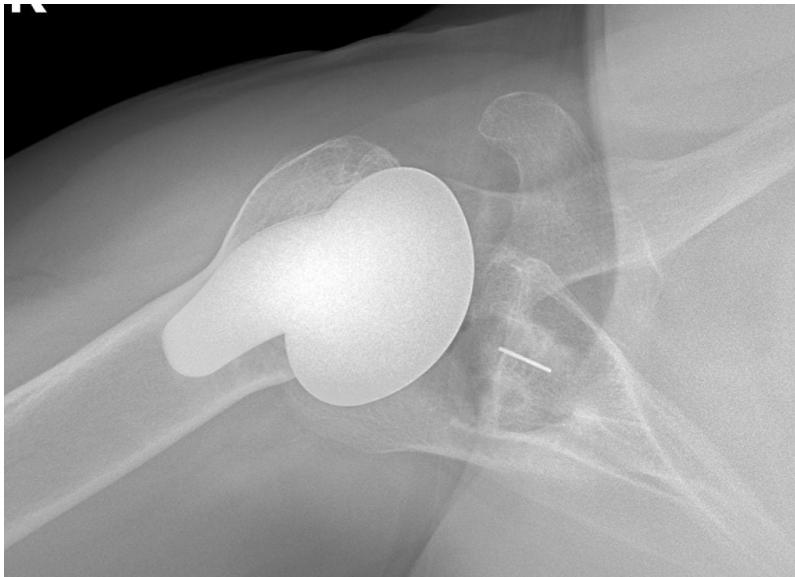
This radiograph shows an axillary view of the right shoulder in a patient three years after a stemmed anatomic total shoulder arthroplasty.
